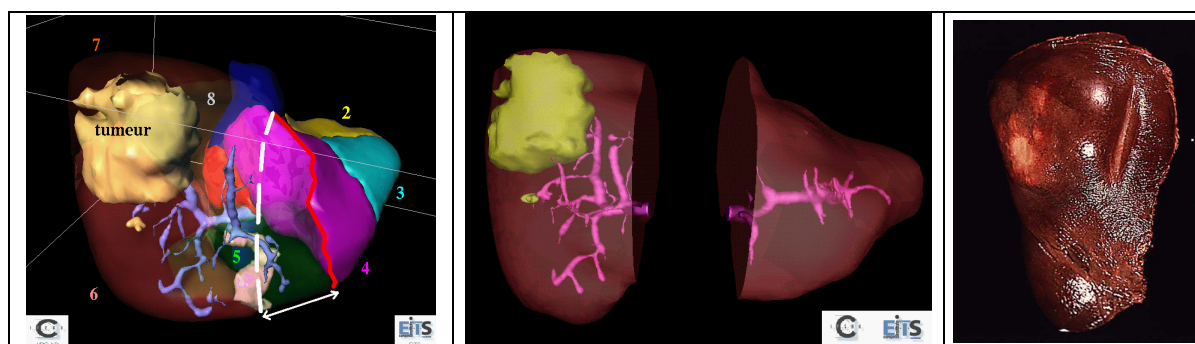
automatic delineation of a tumor and the anatomical segments. The result shows that the segment 8 contains a part of the tumor which was initially not visible from the CT-scan but verified after surgery.
